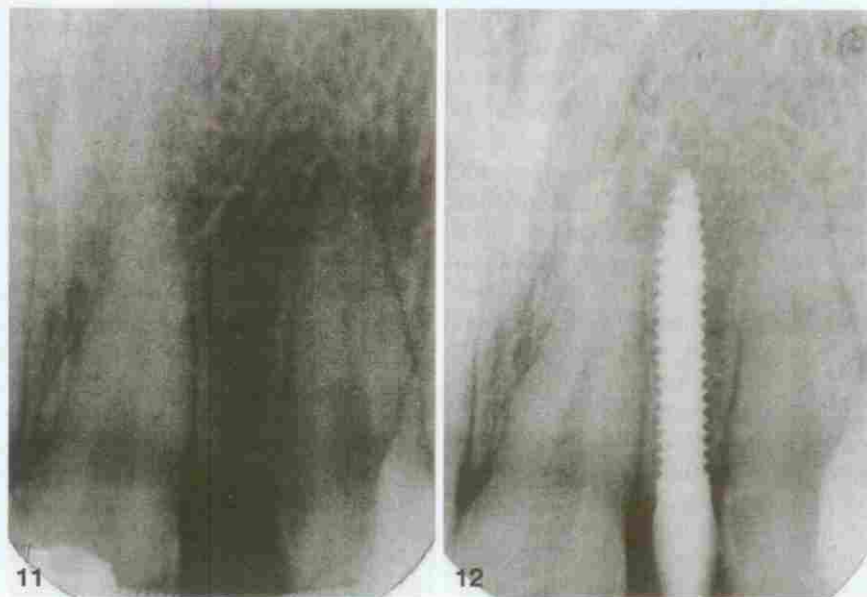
Preoperative apical radiograph.
